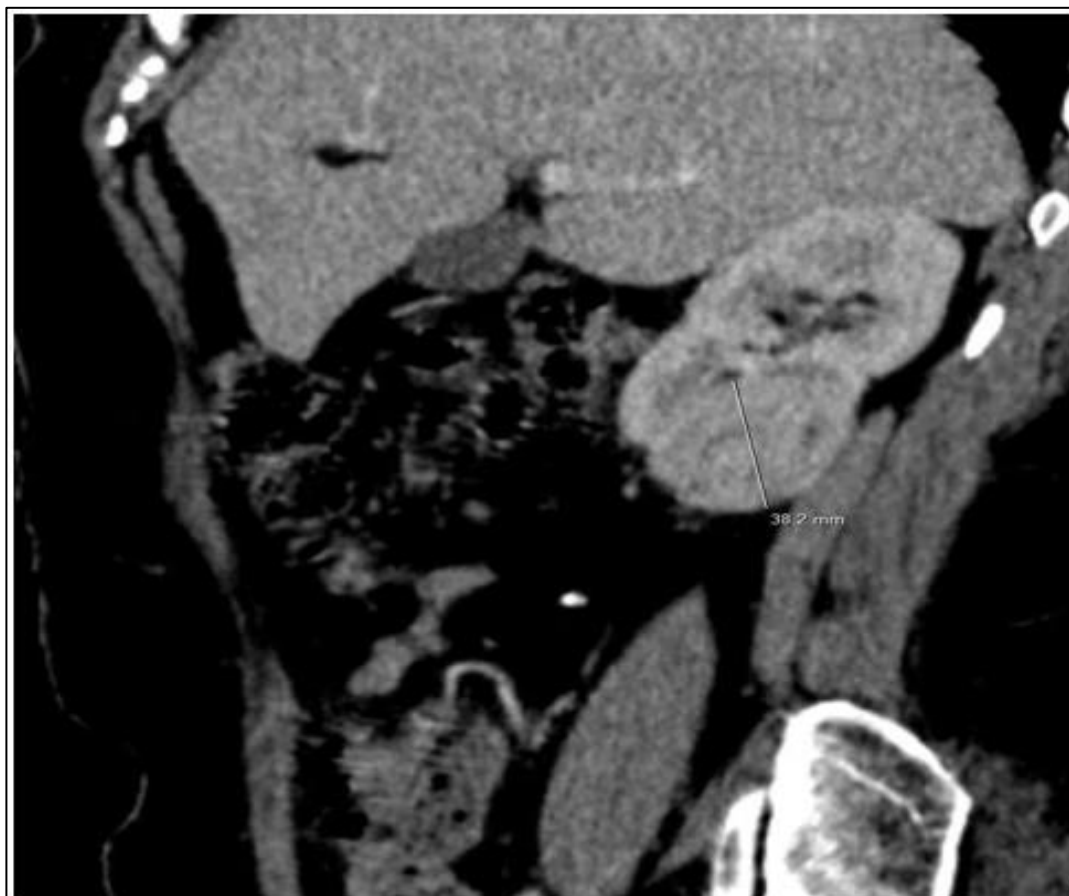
Sagittal Reconstruction of CT scan injected at Parenchymal Time Showing an Inferior Polar Mass O the Right Kidney
